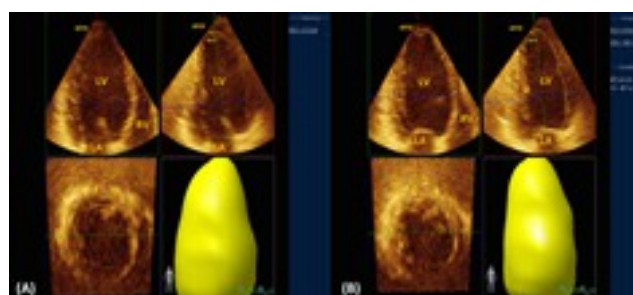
Measurement of left ventricular ejection fraction (EF) using three-dimensional echocardiography. Fig.2A: End-diastolic tracing. Fig.2B: End-systolic tracing.
